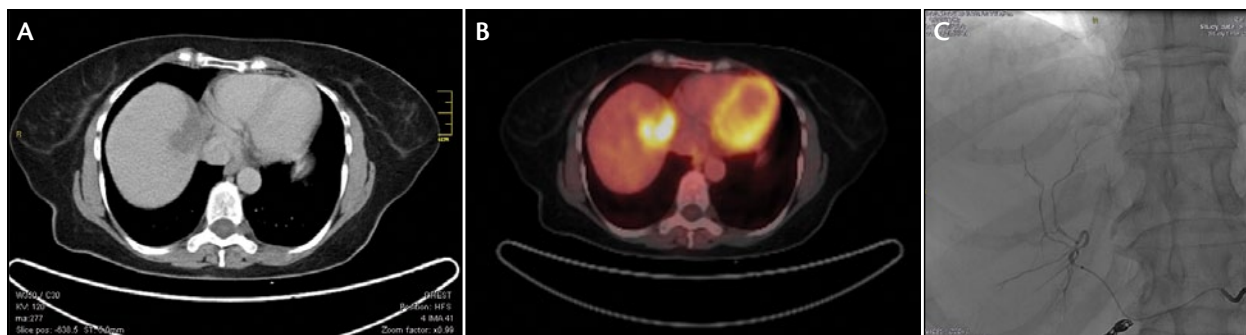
Metastatic CRC treated with Y-90 resin microspheres as salvage therapy shows partial response after radioembolization. Axial noncontrast CT (A) and axial-fused FDG PET/CT (B) of a patient with liver metastases from colorectal carcinoma before treatment shows large hypermetabolic liver lesion. Arteriogram obtained during radioembolization to the target area (C).
